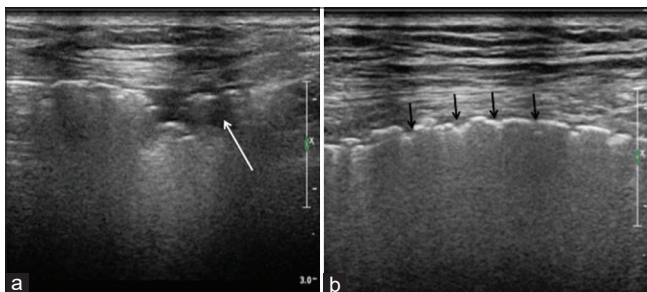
(a) Lung ultrasound performed using linear transducer shows hypoechoic subpleural changes (white arrow) and (b) fragmented pleural line (black arrows)
